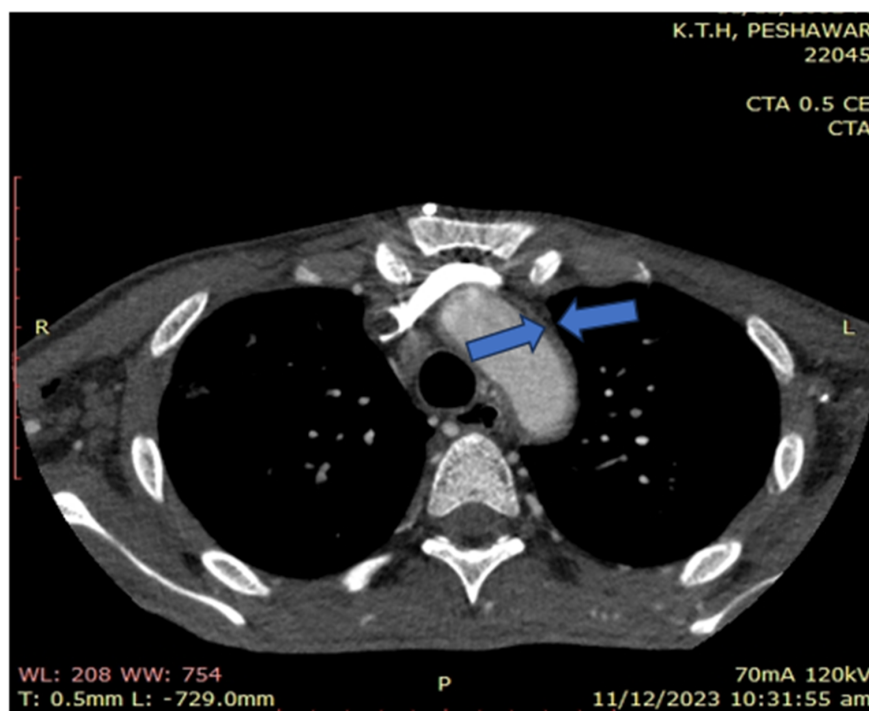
CTA showing thickening of wall of arch of aorta (blue) suggestive of Takayasu arteritis.
